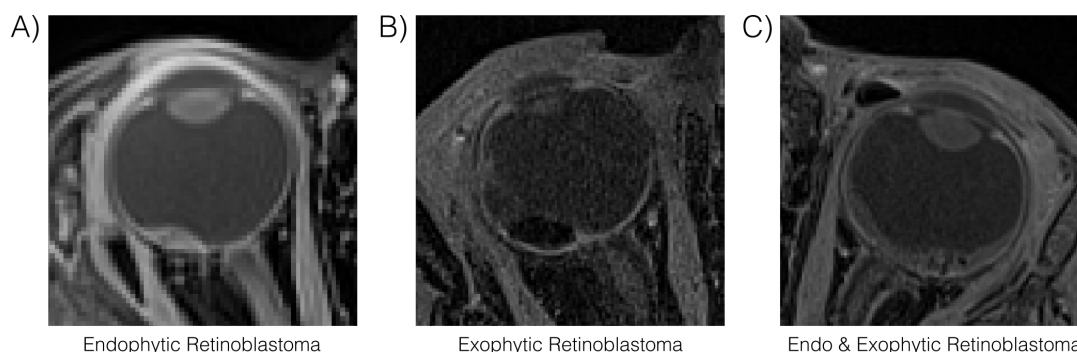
Different types of retinoblastoma tumor in MRI : These pictures show an A) Endophytic retinoblastoma, B) Exophytic retinoblastoma and a C) patient with a combination of Endo- and Exophytic retinoblastoma (as well as a partial retinal detachment due to the tumor presence).
